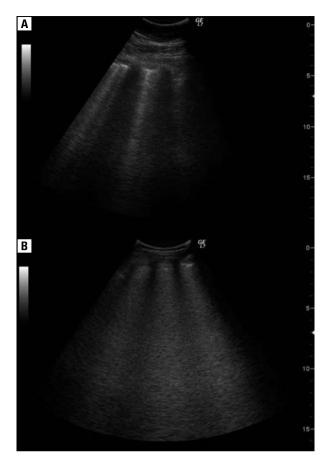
Ultrasound scan of a single B-line in a normal lung (A) and interstitial syndrome in pulmonary oedema called 'white lung' (B)
